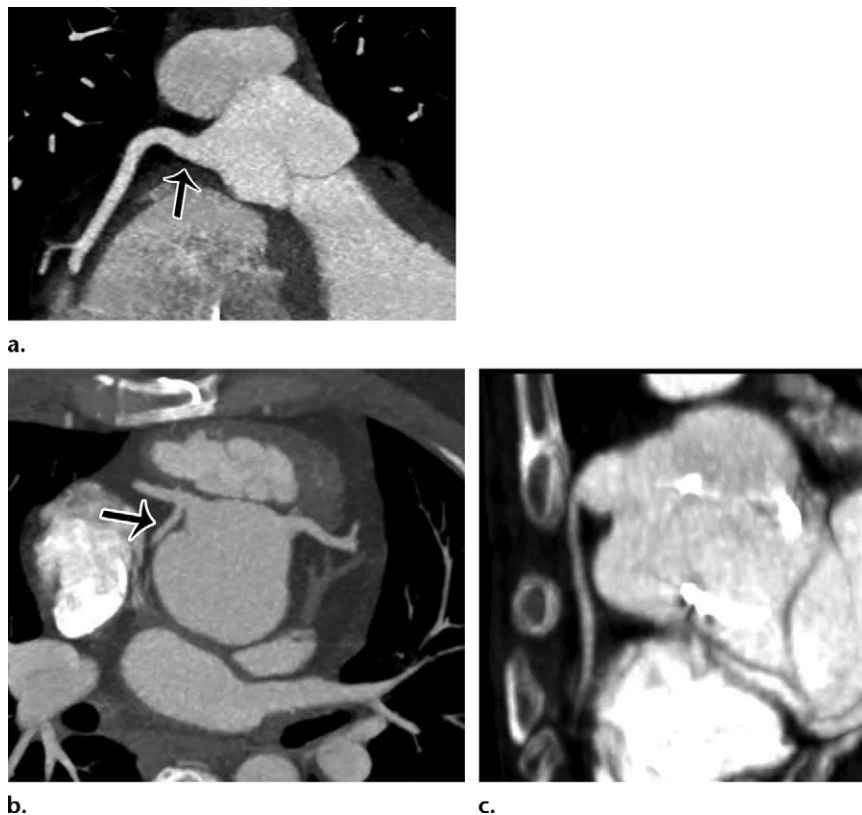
Postoperative imaging appearances in three patients with a history of coronary arterial reimplantation. (a) A 22-year-old man with a history of dextro-transposition of the great vessels (D-TGA) after a coronary arterial switch procedure. Coronal oblique MIP image from coronary CT angiography demonstrates mild broadening (arrow) of the origin of the RCA at the level of reimplantation secondary to the button reimplantation technique. (b) A 17-year-old male adolescent with a history of D-TGA after an arterial switch procedure. MIP image from coronary CT angiography demonstrates reimplantation of both coronary arteries onto a single cusp. Note the retroaortic circumflex artery (arrow) arising from the RCA. (c) A 21-year-old man with a history of Loeys-Dietz syndrome after aortic root and valve replacements with button reimplantation of the coronary arteries. Oblique MIP image from coronary CT angiography demonstrates apparent aneurysmal dilatation of the button of aortic tissue at the level of the anastomosis, which can be a normal postoperative appearance.
